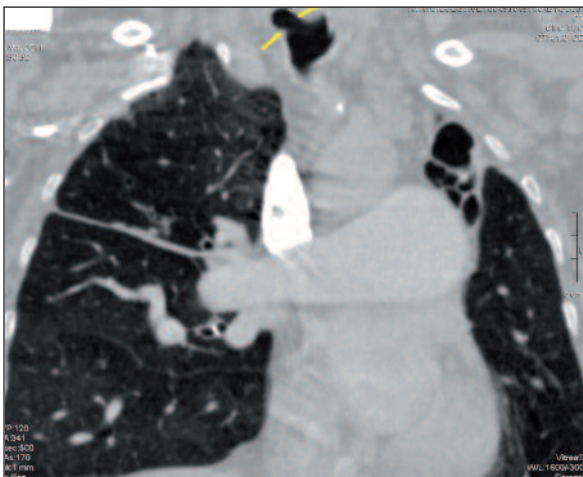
Chest CT scan in coronal plane. The tracheal diverticulum appears posterolaterally of the trachea.
